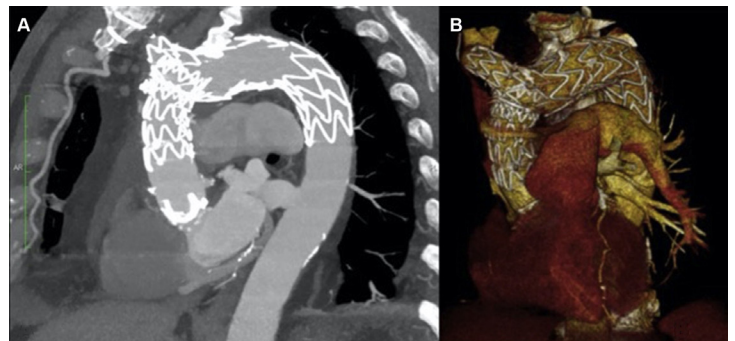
Six-month computed tomography angiogram control.
